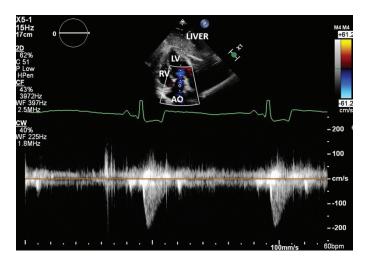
The Doppler cursor is aligned with aortic flow leaving the left ventricle on this subcostal 5 chamber view. Using continuous wave (CW) Doppler, flow is recorded all along the Doppler cursor with no site specificity. Flow along this cursor varies dependent on location, and so the flow profile shows all of these velocities. The flow profile is filled in because of these various velocities, but the highest flow is what is seen at the peak of the flow profile.
